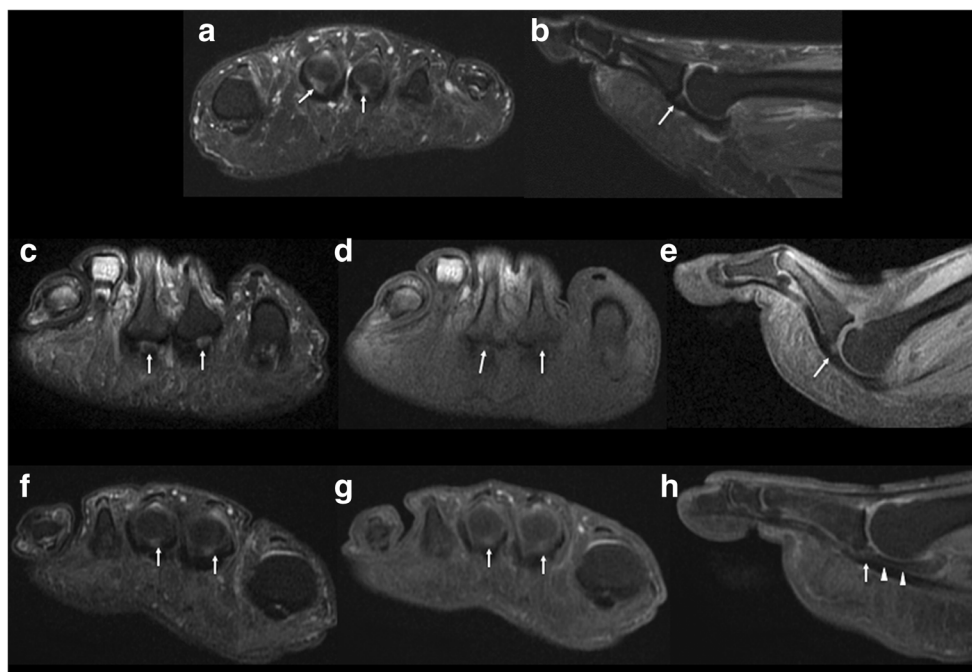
Coronal short (a) and sagittal axis (b) proton-density-weighted fat-suppressed images obtained in a 49-year-old female with forefoot pain and intact PP. *White arrows* indicate increased signal intensity near the distal attachment (central area), that should not be confused as PP tear, and can represent PP recess or hyaline cartilage undercutting the PP phalangeal insertion. Coronal short axis (c) proton-density-weighted fat-suppressed image and coronal short (d) sagittal axis (e) contrast enhanced fat-suppressed T1-weighted images, obtained in a 50-year-old female with metatarsalgia and dorsi-flexion MTP joint. *White arrows* also
